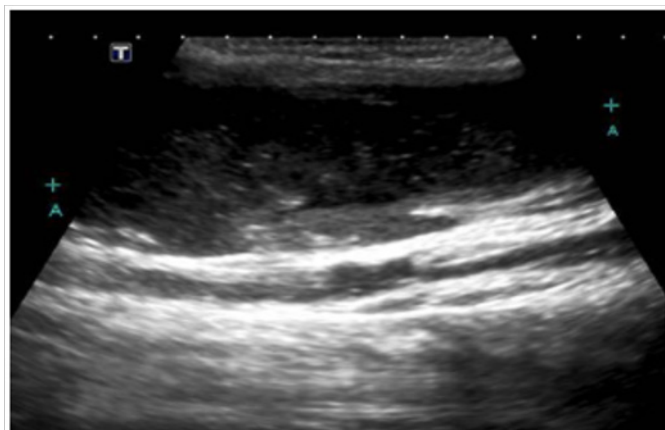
Abscess on the right arm on the ultrasound.
